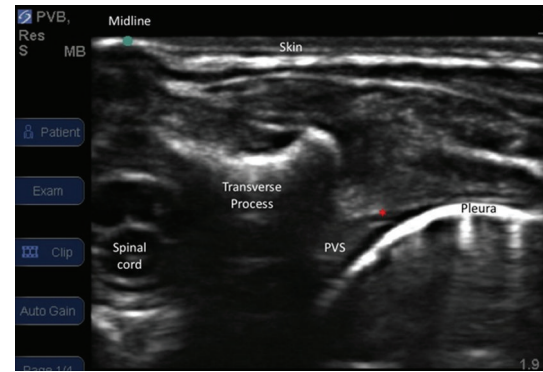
Ultrasound view of paravertebral space. Probe in a transverse paramedian position. *Internal intercostal membrane.
